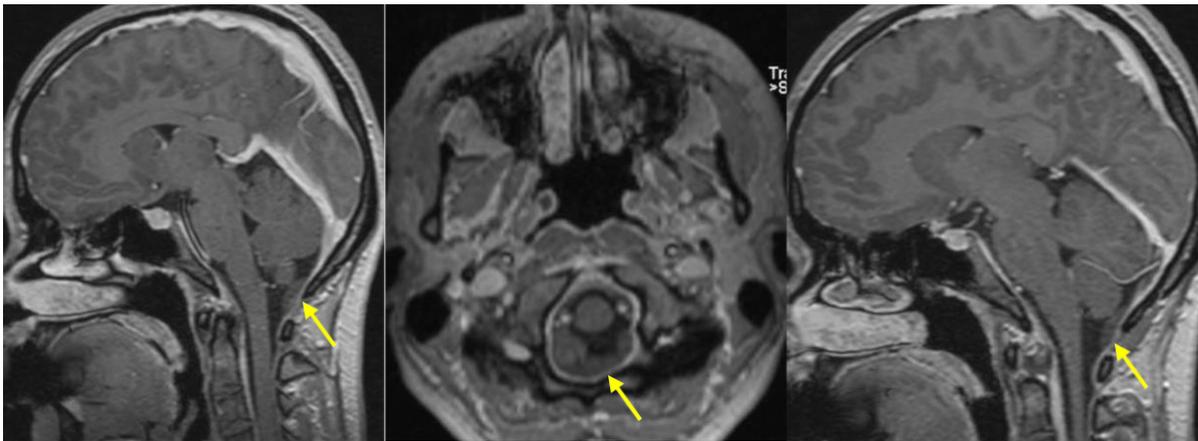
Second MRI during hospitalization in Germany in May 2025 was considered normal. When her headache progressed, the local neurologist there performed another head MRI with contrast: considered normal. Once in Albania, revisiting the two MRIs, a non-enhancing extracerebral lesion of the atlanto-occipital membrane persisted and was not notified (yellow arrow).
